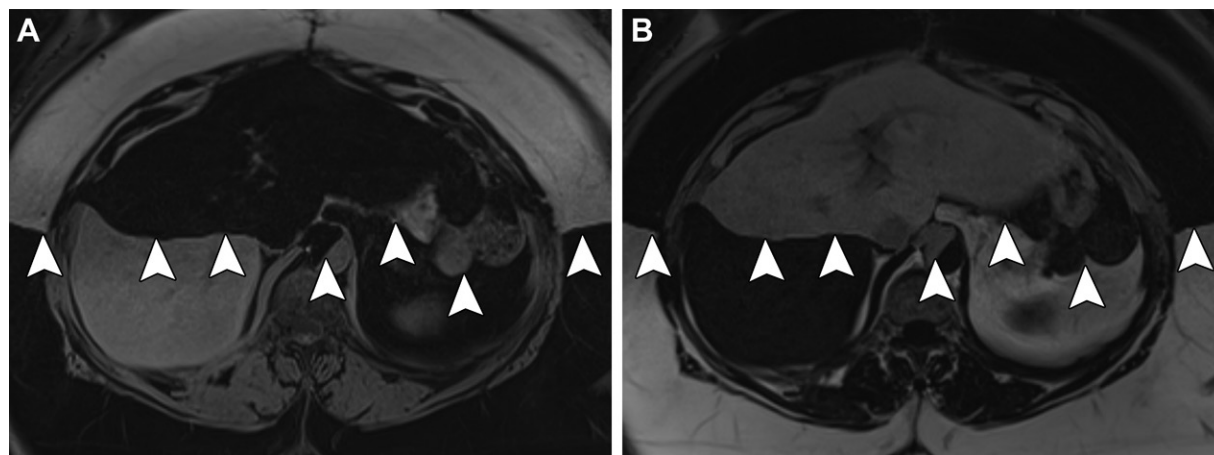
Dixon fat-water swap in a 60-year-old woman who underwent MRI of the abdomen and pelvis. Axial water-only Dixon MR image (A) shows unexpected fat-water swap anterior to a line demarcated by the arrowheads, where mathematical swap of where they should have been assigned has resulted in subcutaneous fat anteriorly being hyperintense and liver signal intensity similarly being misassigned. Axial fat-only Dixon MR image (B) shows corresponding fat-water swap, where subcutaneous fat anteriorly is hypointense and liver signal intensity anterior is incorrect.
